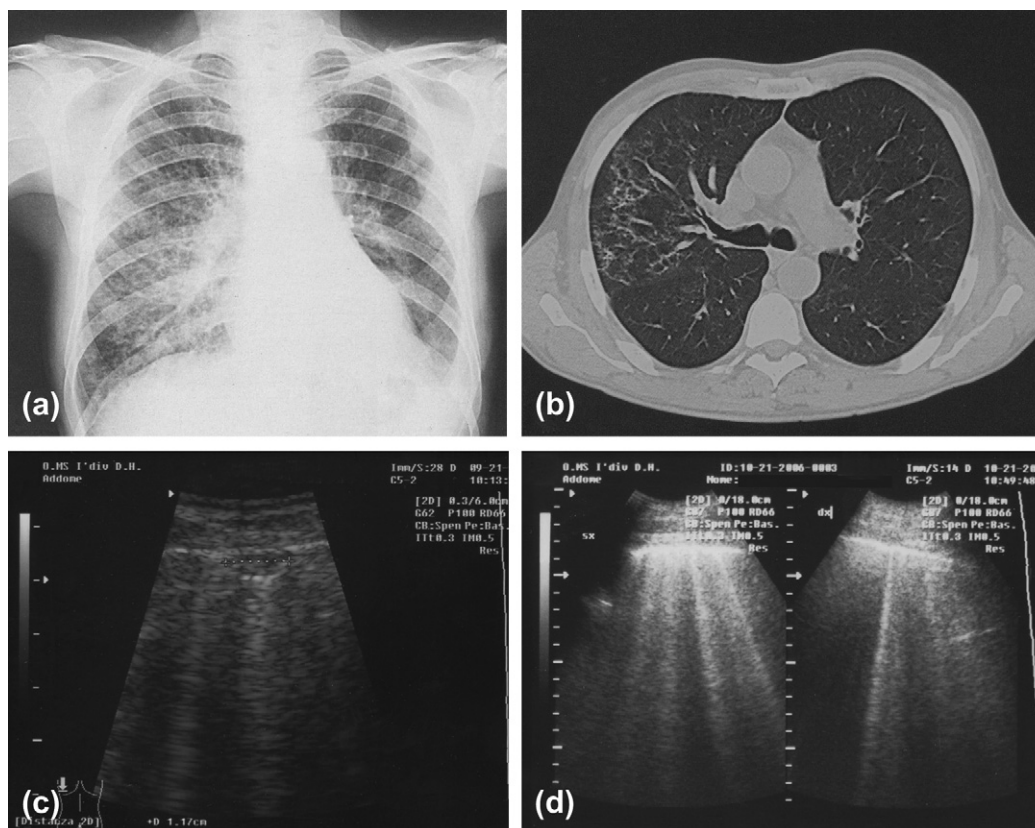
Pneumocystis carinii* infection in an HIV+ subject. (a) Radiological findings; (b) CT; (c) subpleural hypoechoic zone; and (d) ring-down artifact.
